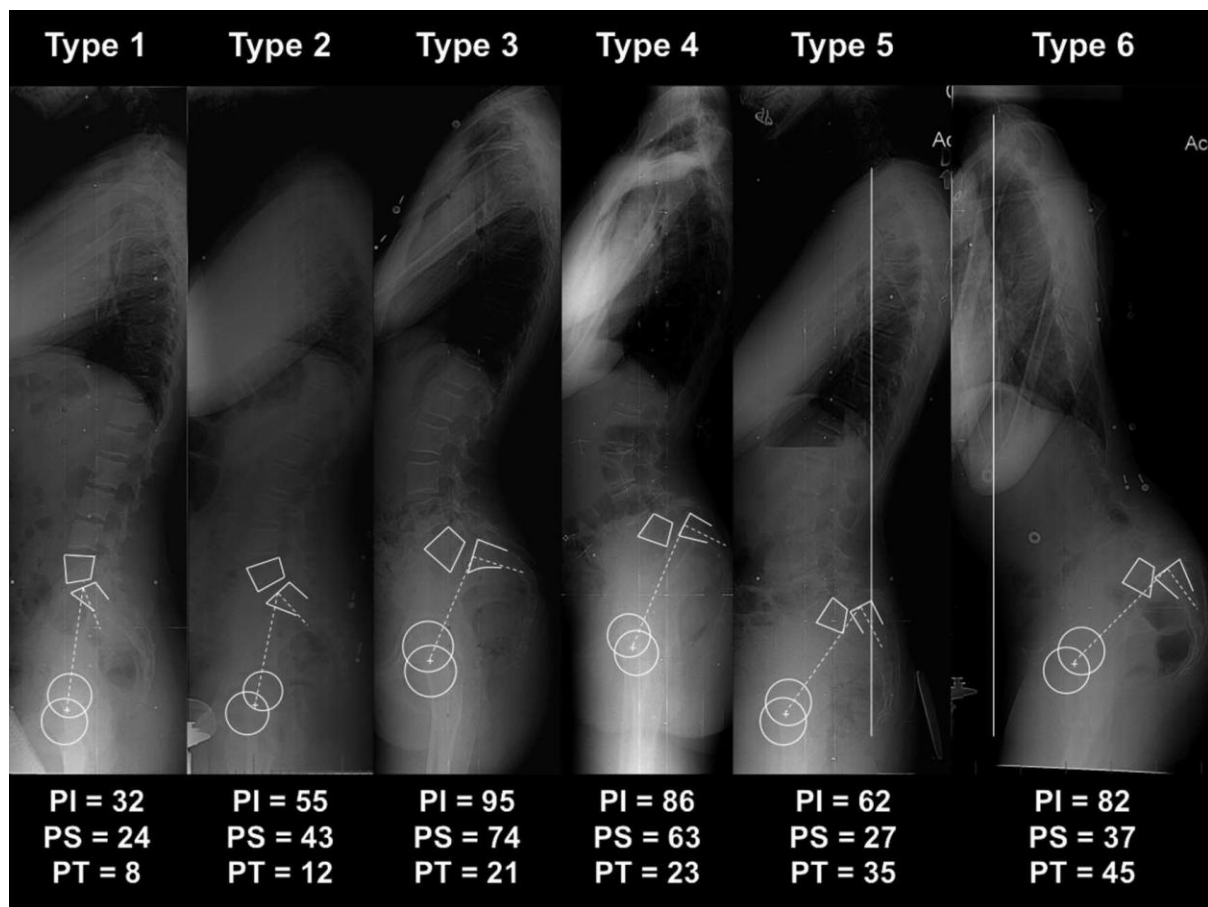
showing the Xrays of various classes of spondylolisthesis according to the SDSG classification. (36)
